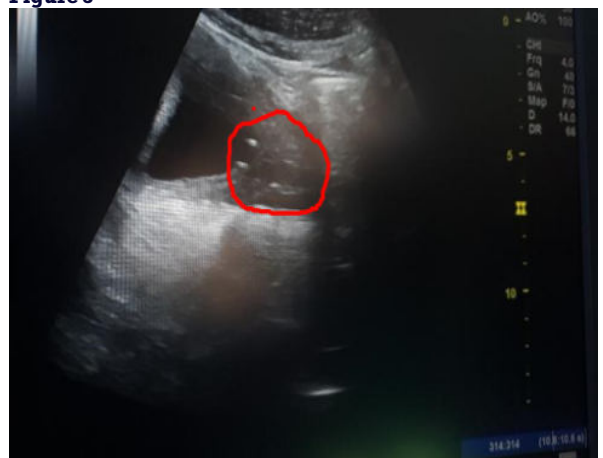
Beads as seen on Ultrasonography.
